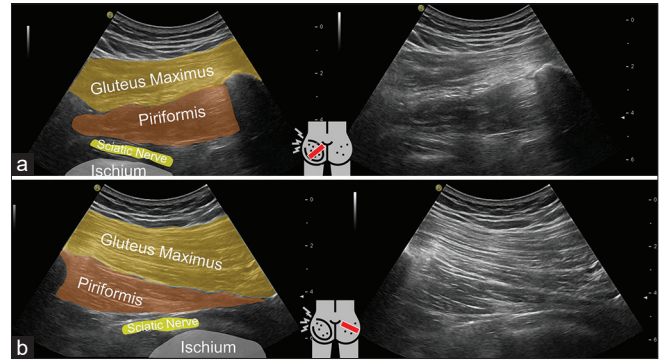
Ultrasound images of the posterior hip showed the left piriformis muscle (a) normal side (b)
